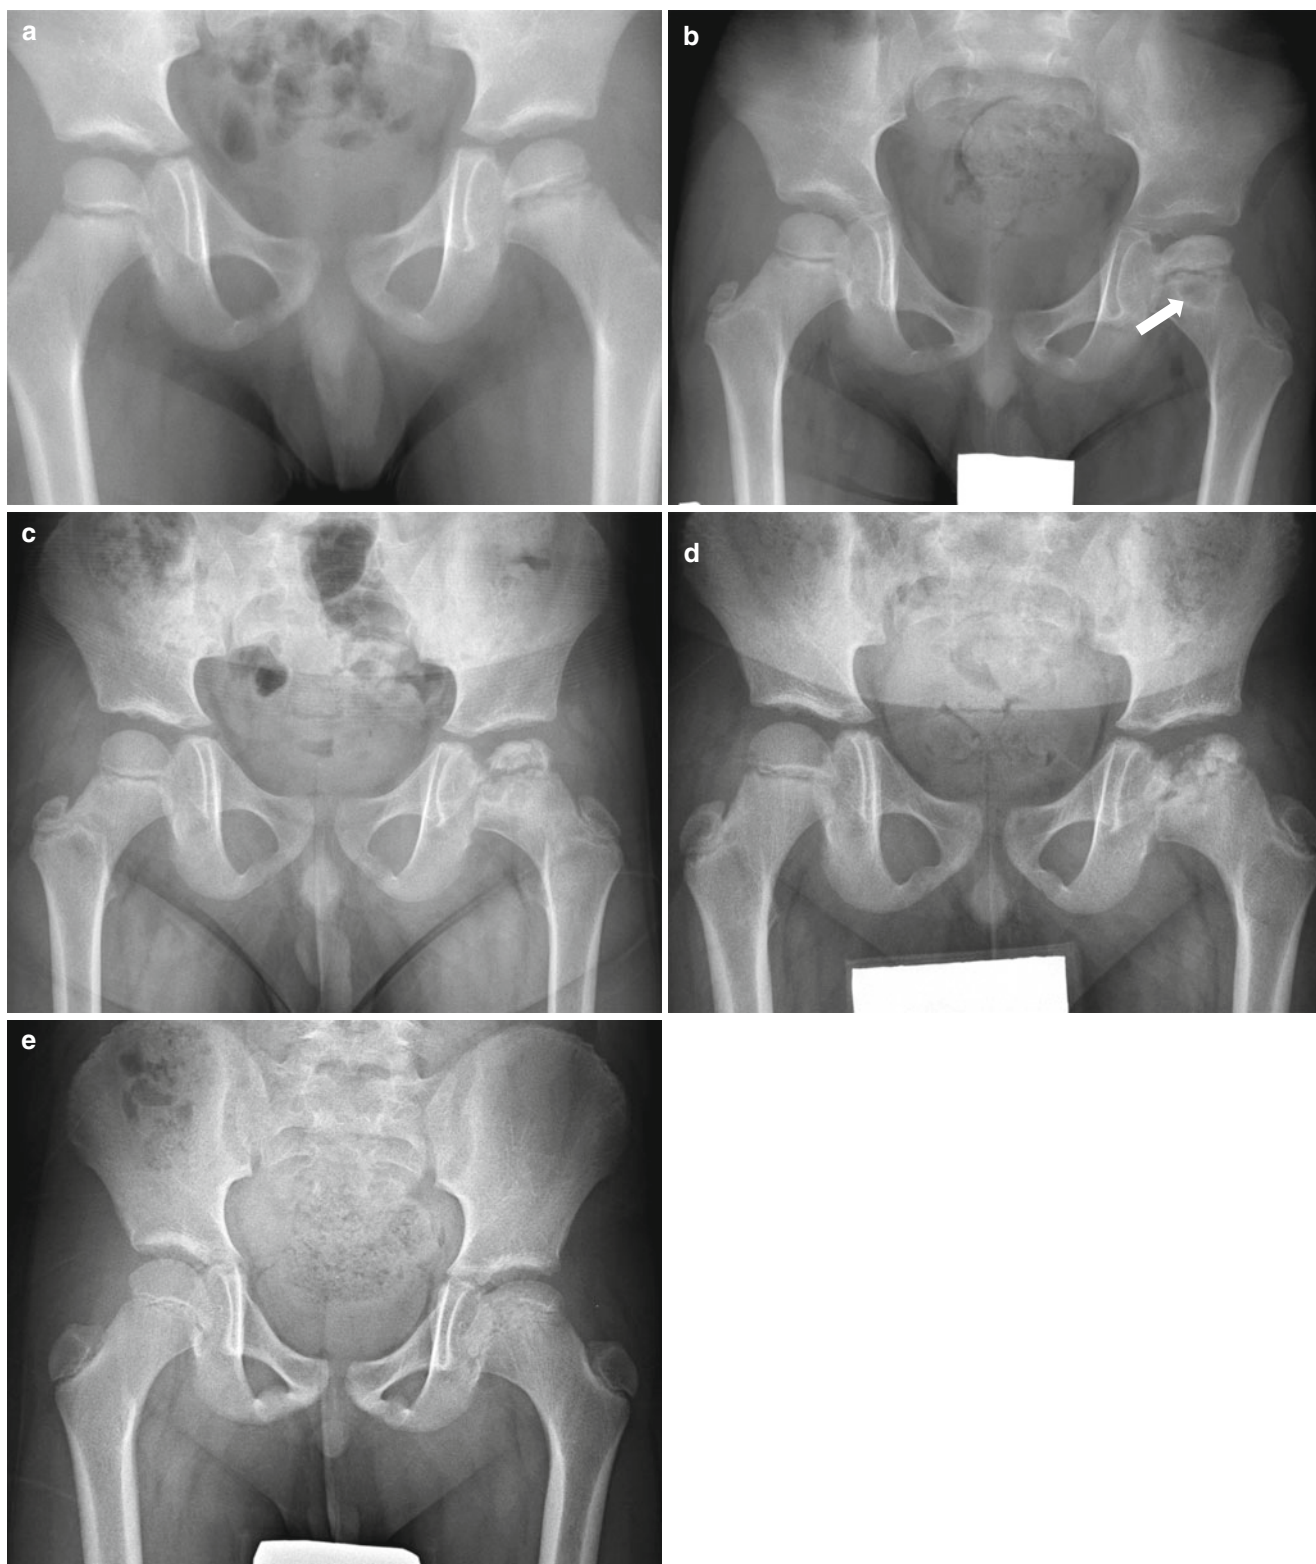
Evolution of radiographic abnormalities in LCP disease. (a) Initial radiograph in a 6-year-old boy with left limping gait shows no specific abnormality. (b) Anteroposterior radiograph obtained 6 months later shows increased sclerosis and slight asphericity of the left femoral head. Note the radiolucent area with sclerotic rim (arrow) in the left
